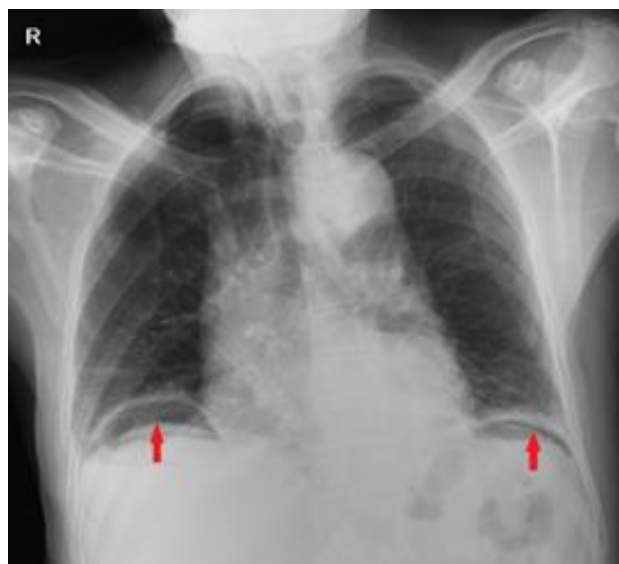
Free air under the diaphragm in chest X-ray
